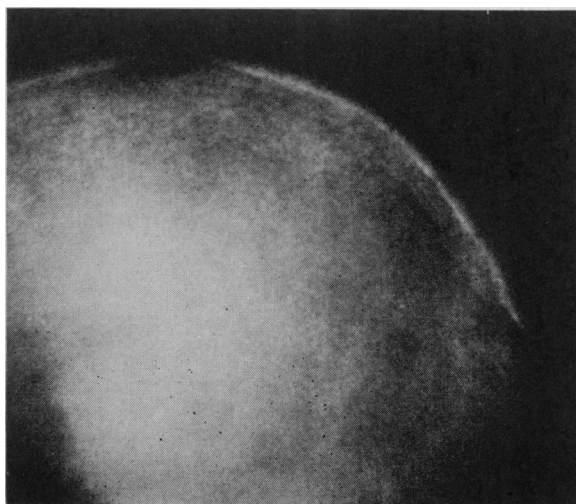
Section of roentgenogram of skull revealing characteristic granular osteoporosis of hyperparathyroidism.
